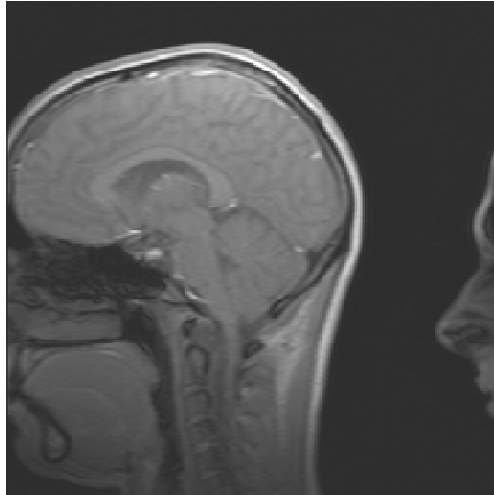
Example of fold-over artifact in an MR image. Phase-encode direction is left-right in the image. The nose extended outside the field-of-view (FoV) but still contributes to the MR signal and is therefore folded back into the image on the opposite side.
